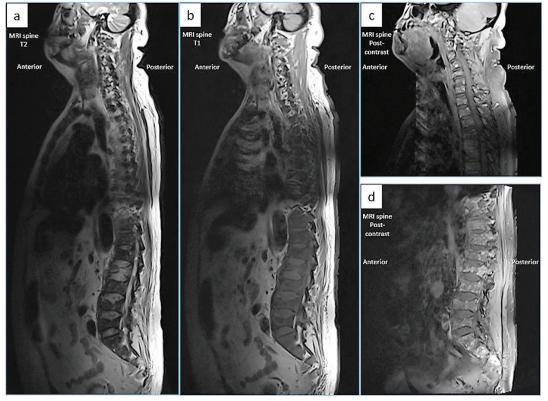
MRI (whole spines) showing multiple compression fractures T4, T12, L1, L2, L4, L5 vertebral bodies and multiple lytic bone lesions
